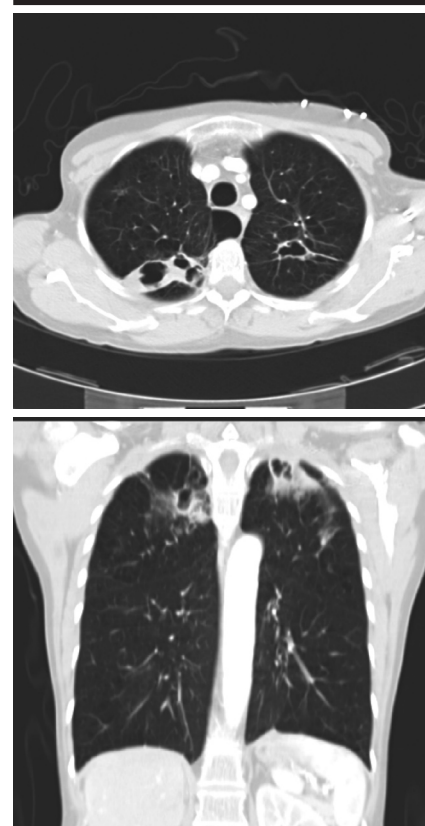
Chest Computed Tomography before left upper lobectomy was performed, March 2008. Coronal and frontal planes with findings of caverns in both upper lobes.
